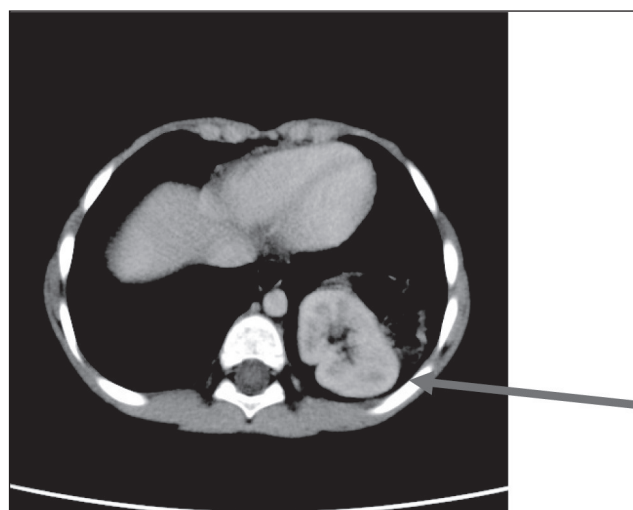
CT of the chest, arrows shows ectopic kidney.
